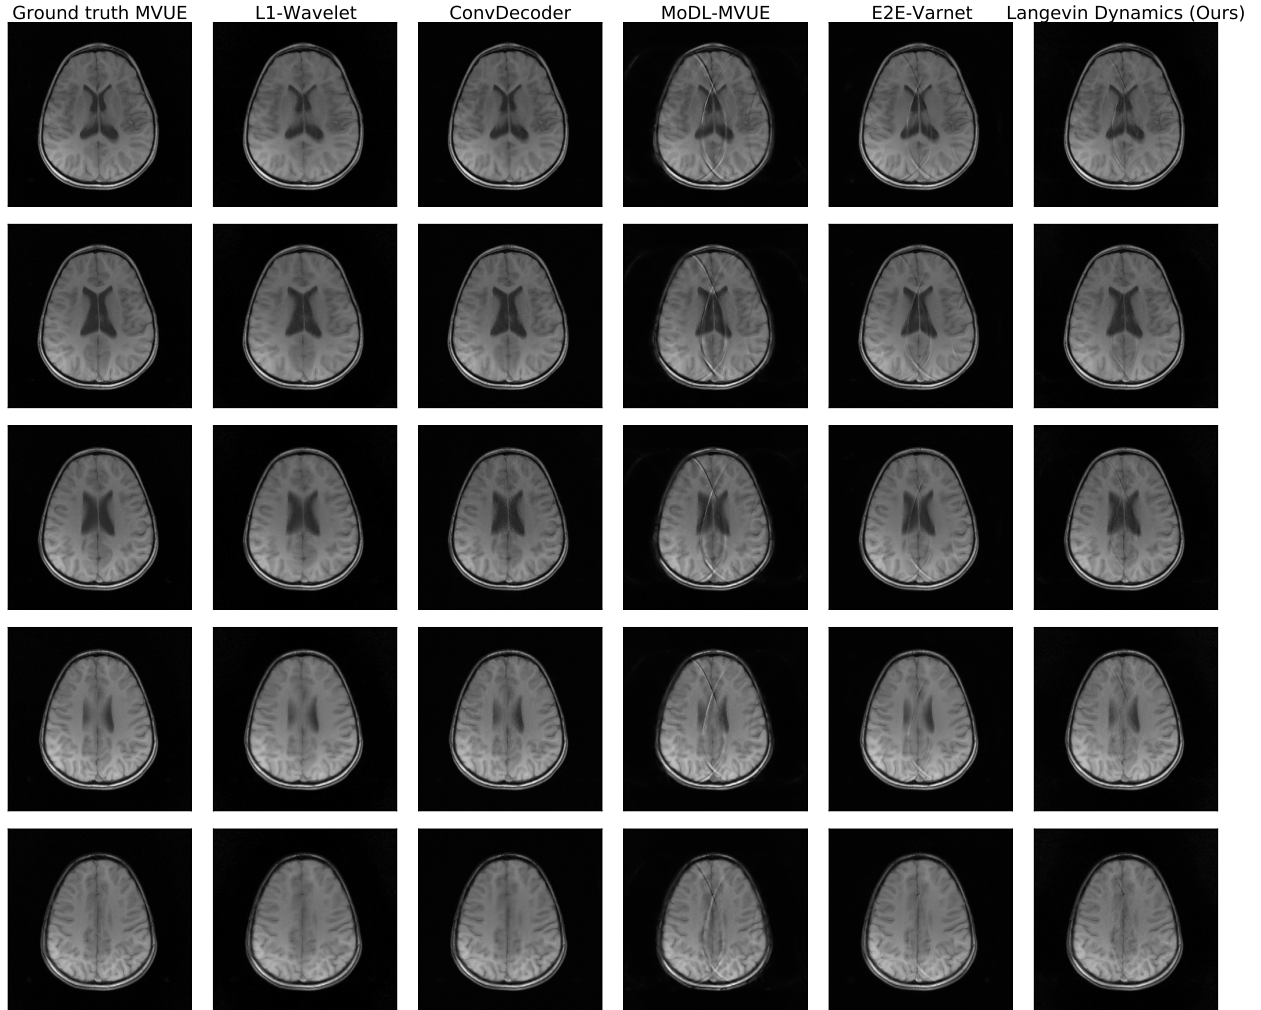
Brain reconstructions under a contrast shift, at an acceleration of $R = 4$. Our method was trained on T2-weighted brains, while these are T1-weighted brains, and our method is clearly robust to this contrast shift.
